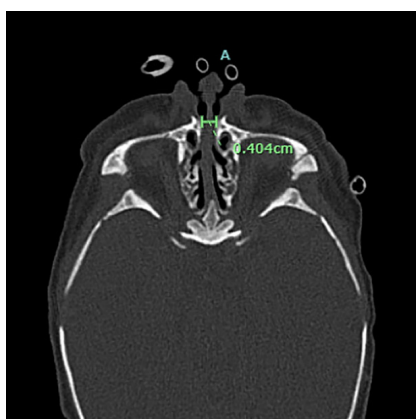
An axial maxillofacial computed tomography image of a neonate with respiratory distress and stertor notes a narrow pyriform aperture measuring 4mm (green measurement) in the anterior nasopharynx. Image from: Burch JL, Whitesel E, Manzi B, Adil E. A neonate with obstructed nasal breathing. *Neoreviews*. 2023;24(3)e195.10.1542/neo.24-3-e195¹
